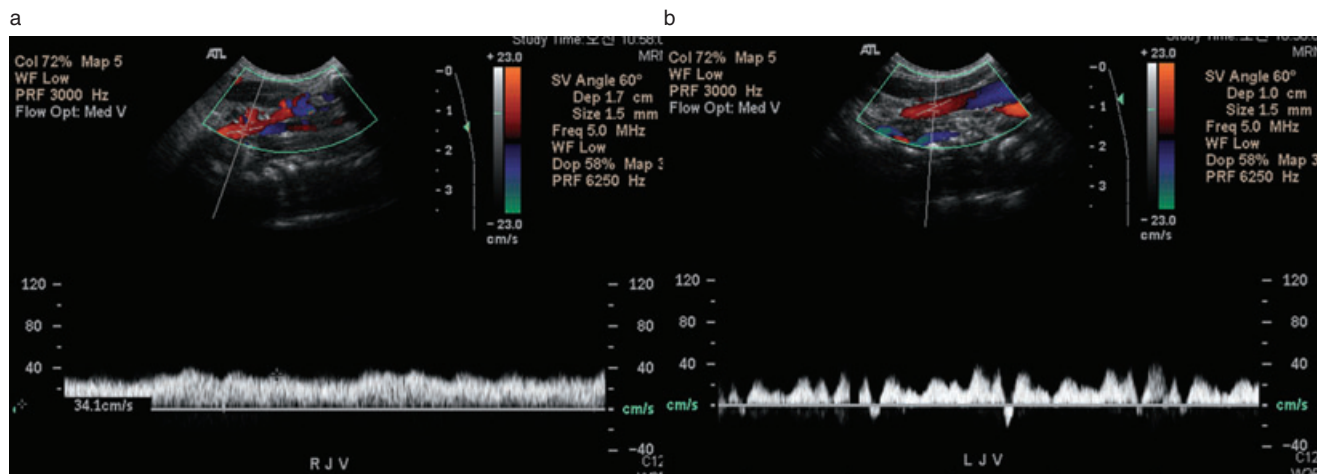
Pulse wave Doppler study showed abnormal monotonous blood flow waveforms in the right internal jugular vein in which the central venous catheter was placed (a). The normal biphasic blood flow was observed in the contralateral internal jugular vein (b).
